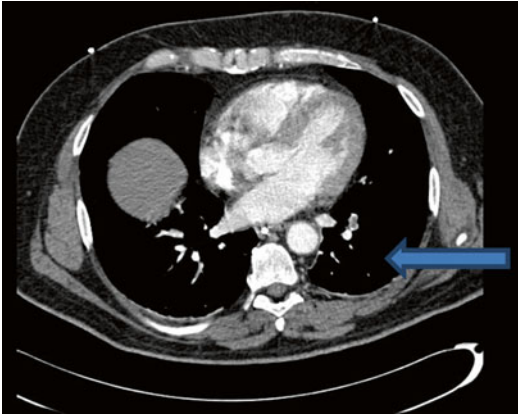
CT angiogram of the pulmonary vessels demonstrating acute pulmonary emboli in the segmental arteries of the left lower lobe (see arrow)
